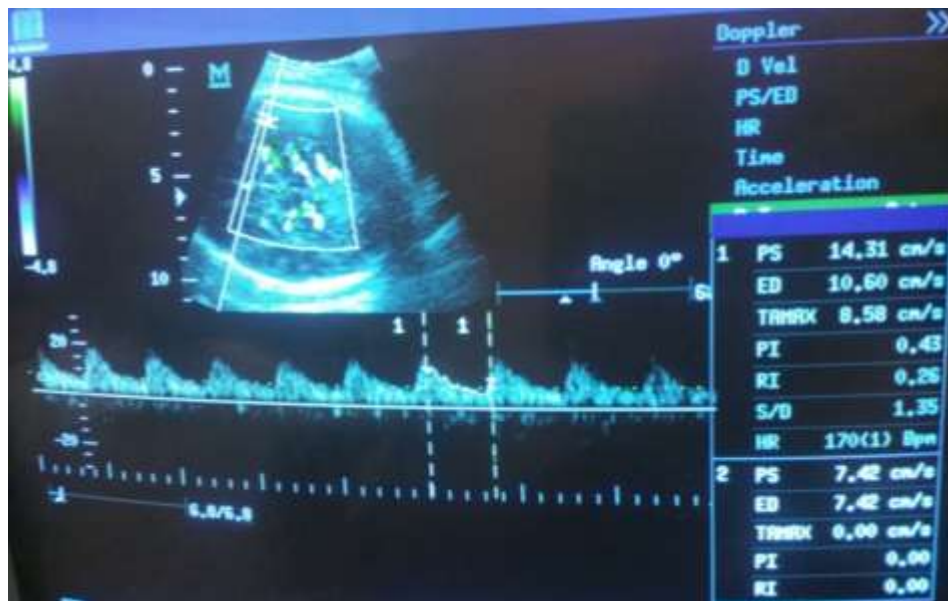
b) shows color Doppler middle cerebral artery waveform at 37 WKs
